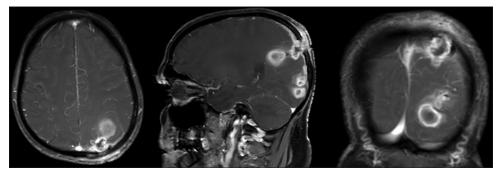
Follow-up contrast-enhanced magnetic resonance imaging showing compartmentalized lobulated lesion with few discrete ring-enhancing lesions and no new lesions
